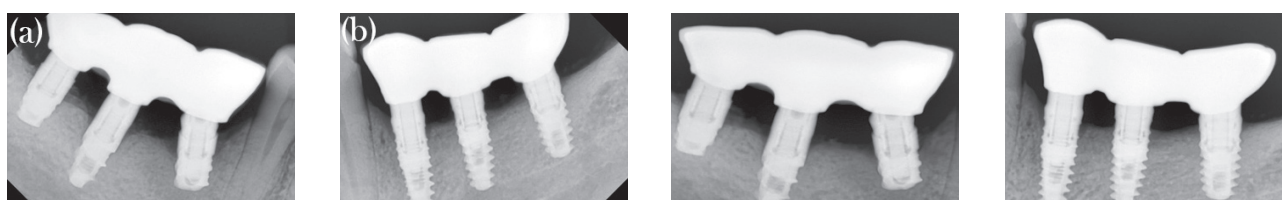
Radiographs of prostheses at 18 months.
